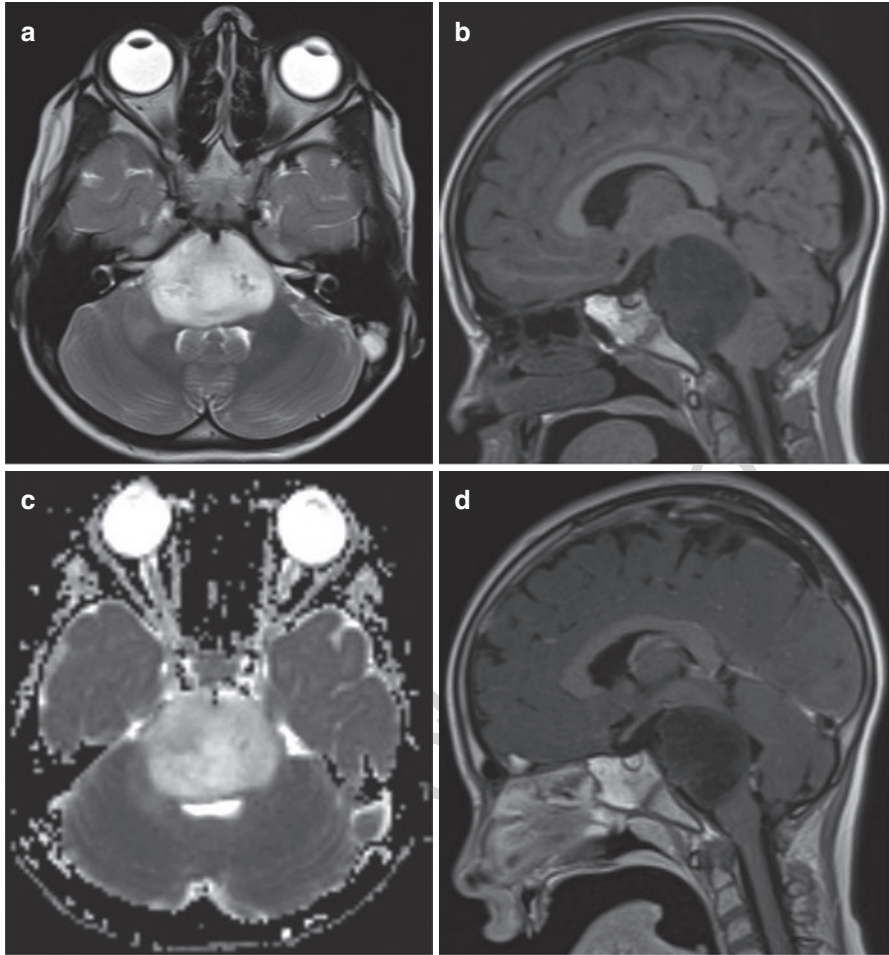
Typical MR characteristics of DIPG, with large pontine mass, hyper-intense on T2-weighted axial image, encircling the basilar artery ventrally (a), and clearly delineated by the ponto-medullary junction on sagittal T1 sequence (b). The tumour does not restrict on diffusion-weighted imaging (c) and does not enhance on gadolinium administration (d)
